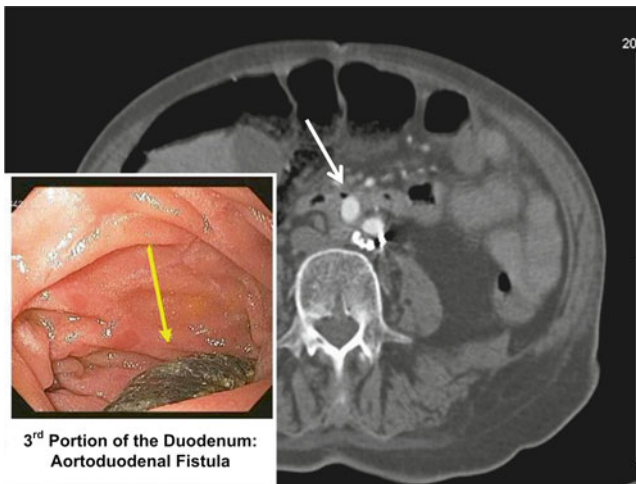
CT scan showing an air pocket on the anterior surface of a limb of an aortobiliac bypass graft (white arrow) at the level of the duodenum. The inset shows exposed Dacron (yellow arrow) in the duodenal lumen
